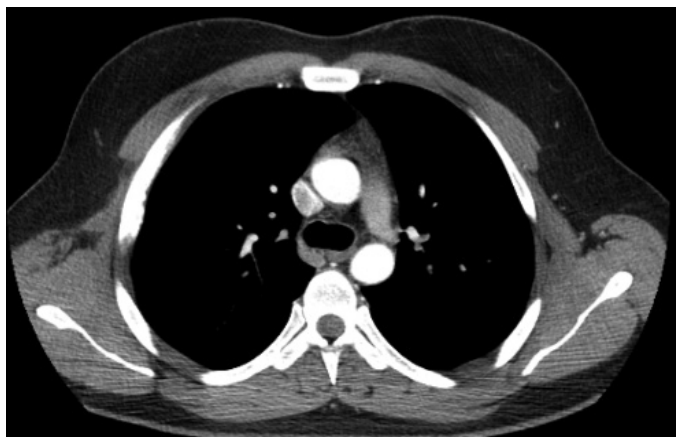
Chest CT, there was no soft tissue
